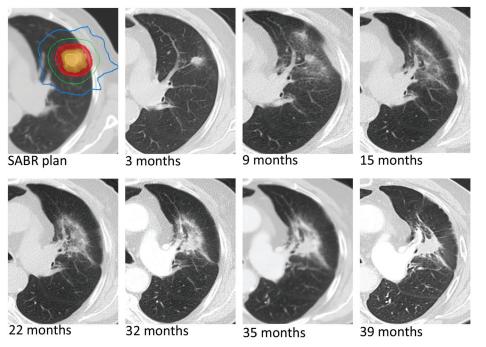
SABR plan and follow-up imaging for the patient described in Figure 1. Serial CT chest follow-up were scans obtained at 3, 9, 15, 22, 32, 35, and 39 months after radical treatment. The patient was not a candidate for salvage interventions and thus was monitored throughout without repeat biopsy. There was no change in RECIST measurement beyond 32 months. SABR, stereotactic ablative radiotherapy; CT, computed tomography.
